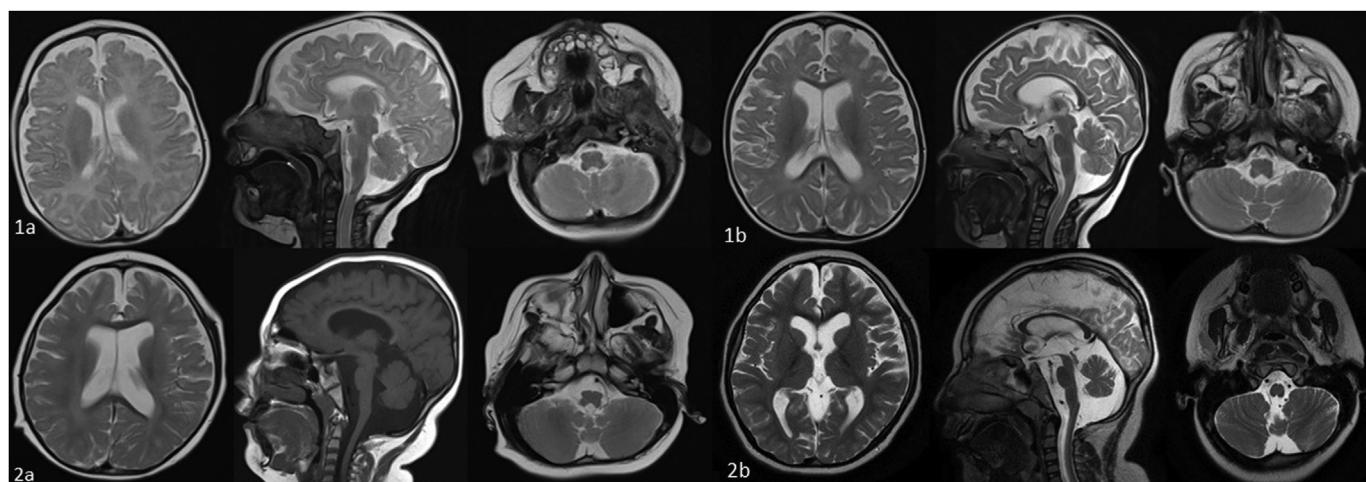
Consecutive magnetic resonance imaging (MRI) of Patients 1 (1a, 1b) and 2 (2a, 2b). In the first MRI of Patient 2, pons hypoplasia, cerebral cortex atrophy, enlarged ventricles, increased signal intensity in white matter, thinning of the corpus callosum, and delayed myelination were observed. In the second MRI, cerebellar atrophy was observed as a novel feature. The myelination was suitable for the patient's age (a: first MRI, b: second MRI).
